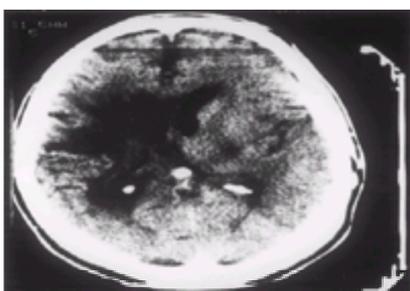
Computed tomographic scan of a man who at age 56 years had a thrombotic stroke causing spastic left hemiplegia, left homonymous hemianopsia, and almost immediate onset of central pain. He was followed over 4 years with a somewhat variable pain and sensory picture until he died of bronchogenic carcinoma. Constant sharp pain was felt in the left shoulder, left hip, and left hand, with spontaneous exacerbations every 2 minutes increased by activity. There was burning pain in the left medial thigh, knee, and foot and cramps in the left calf. Appreciation of light touch, pinprick, position, and vibration sense was reduced on the left side, although he was an inconsistent witness and the degree of position and vibration senses varied; there was mild allodynia to light touch, mild hyperpathia, inconsistently localized, to pinprick and severe cold allodynia. He was treated with left deep brain stimulation in periventricular gray inserted December 19, 1990, which reduced his allodynia dramatically at first, less so over the 4 years of follow-up. This induced a warm feeling in the face and chest.
